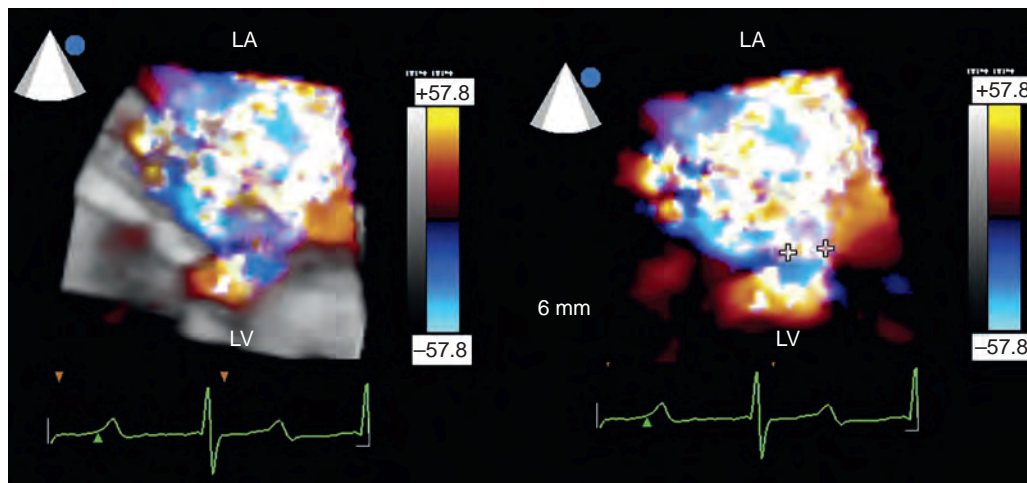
Three-dimensional (3D) color Doppler imaging of a regurgitant mitral jet. The two images demonstrate the use of 3D color Doppler imaging to image flow from multiple levels to see the full shape of, in this case, regurgitant flow. Shown is the evaluation of a paravalvular regurgitant jet of a prosthetic mitral valve. The regurgitant jet is seen below, at, and above the valve to allow a more accurate measure of the vena contracta. As seen in Fig. 15.18, expansion of the regurgitant jet is seen on the atrial side. This expansion helps to understand why the regurgitant jet area may not reflect the regurgitant orifice accurately. In the case, the 3D view of the regurgitant flow aided in determining the size and number of occluder devices. LA, Left atrium; LV, left ventricle.
